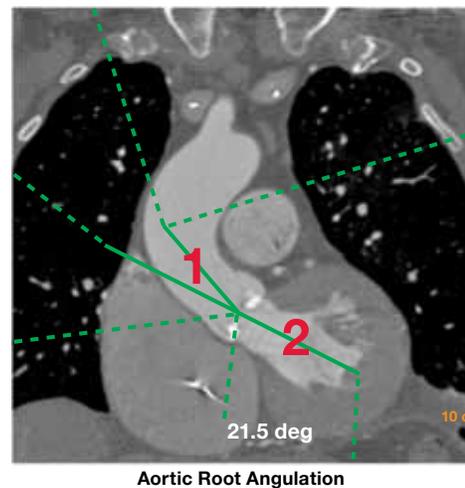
CTA of left ventricular outflow track (LVOT) aortic root angulation (ARA). Measurement of LVOT-ARA is performed using a coronal oblique projection and is defined as the angle between the axis of the first portion of the ascending aorta¹ corresponding to the upper part of the bioprosthesis, and the LVOT axis² corresponding to the distal portion or landing zone of the prosthesis. This measurement is critical for determining whether the prosthesis will properly sit within the aorta. Patients with an LVOT-ARA >90 degrees are not candidates for TAVI.
